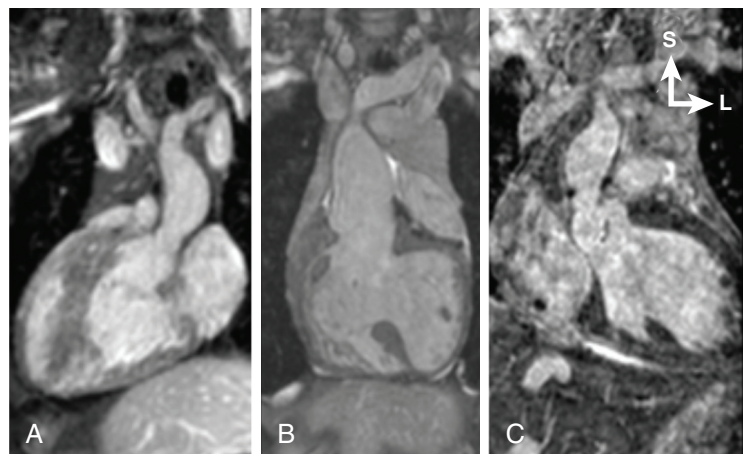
■ Magnetic resonance images obtained using a steady-state free precession sequence reformatted in coronal plane showing: A, Dextrocardia with the apex of the heart to the right. B, Mesocardia with the apices of the ventricles directed inferiorly. C, Levocardia with the apex of the heart to the left. Directional marker applies to all three images. L, Left; S, superior.
